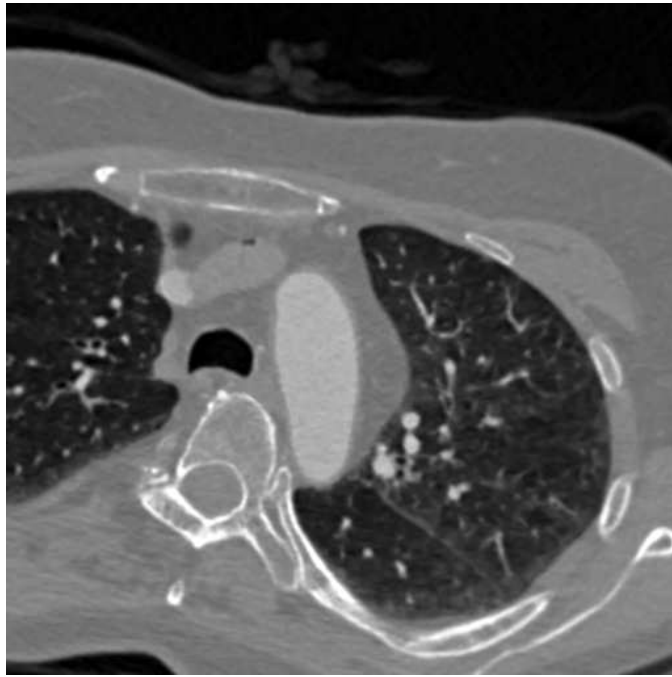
A slice from a CT image stack
